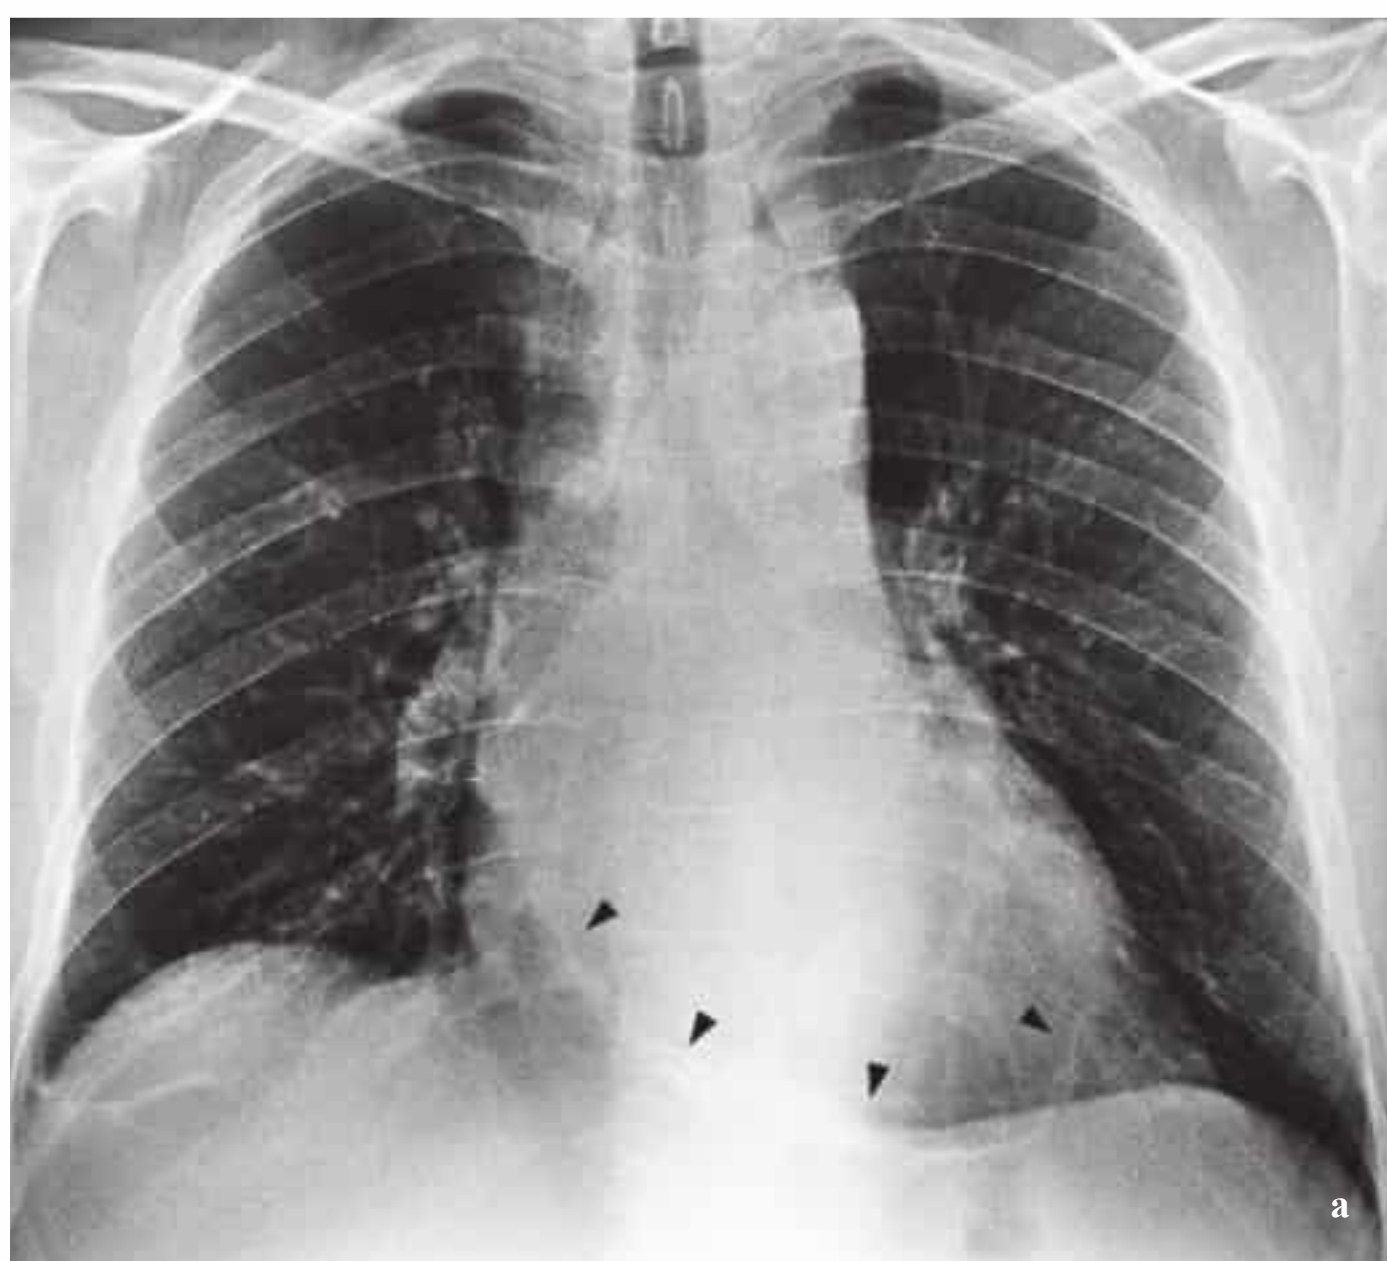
a, b P-A (a) and lateral (b) radiographs in calcific constrictive pericarditis show shell-like calcification along the left cardiac border (a) and anterior and posterior calcified shells extending to the cardiac apex (b).
